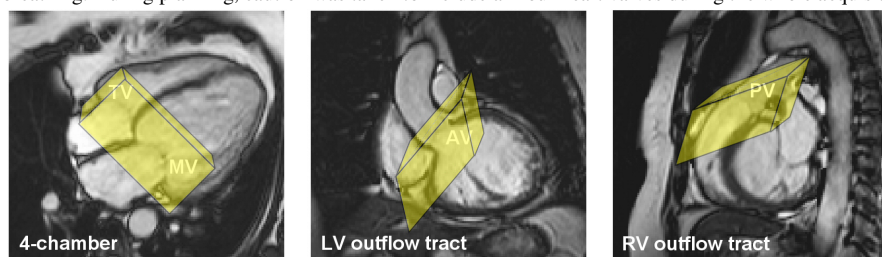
Planning of volume slab for 3D 3-dir VE MRI, with all four heart valves inside the slab during the whole cardiac cycle (LV: left ventricle; RV: right ventricle; MV: mitral valve; TV: tricuspid valve; AV: aortic valve; PV: pulmonary valve).
